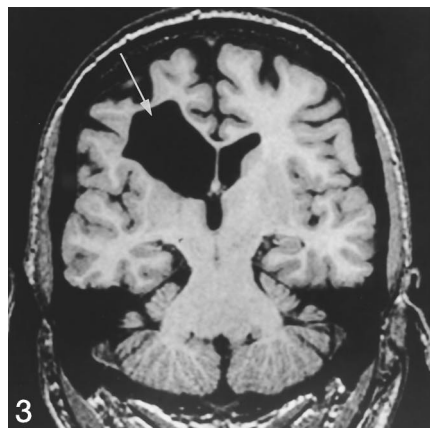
Case 5: volumetric T1-weighted MR image (20/6.2) shows a porencephaly (*arrow*) without hippocampal atrophy in a deep branch of the right middle cerebral artery distribution.
